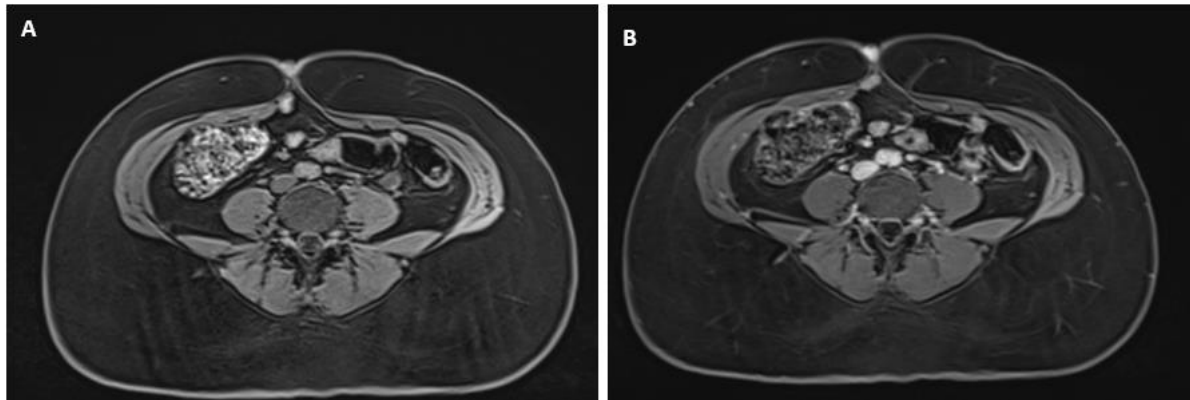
Follow up MRI after three months post Dienogest treatment. A and B axial T1 pre and post contrast images, showed slightly reduction in the size of the umbilicus endometriosis (comparison with Figure 2C).
